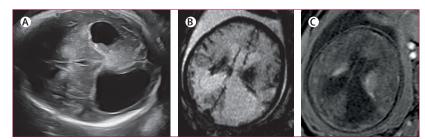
In utero and congenital toxoplasmosis of the brain caused by infection in late pregnancy (A) Axial ultrasound of the fetal brain, at 36 weeks' gestation, shows asymmetric severe lateral ventriculomegaly and increased echogenicity of the deep grey matter nuclei-suggestive of parenchymal calcifications. Axial echoplanar (B) and T1 weighted (C) MRIs of the fetal brain, at 36 weeks' gestation, show ventriculomegaly and findings suggestive of parenchymal calcifications.
